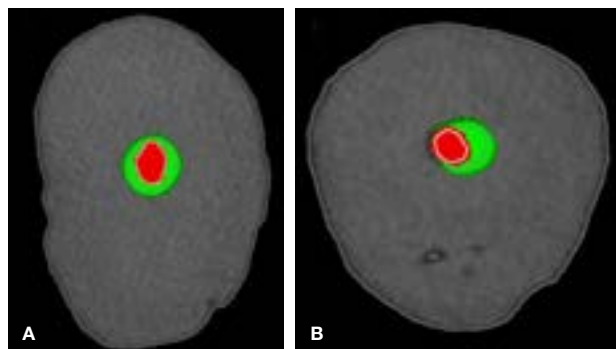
Representative micro-computed tomography examples of mesio-buccal root canal systems of extracted mandibular first molars at the level of 7 mm from from the apical foramen: (A) a centred canal preparation; (B) a non-centred canal preparation that can lead to canal straightening, transportation, thinning of the canal wall and perforation (Red: original canal, Green: canal after preparation with rotary nickel-titanium instrument).
